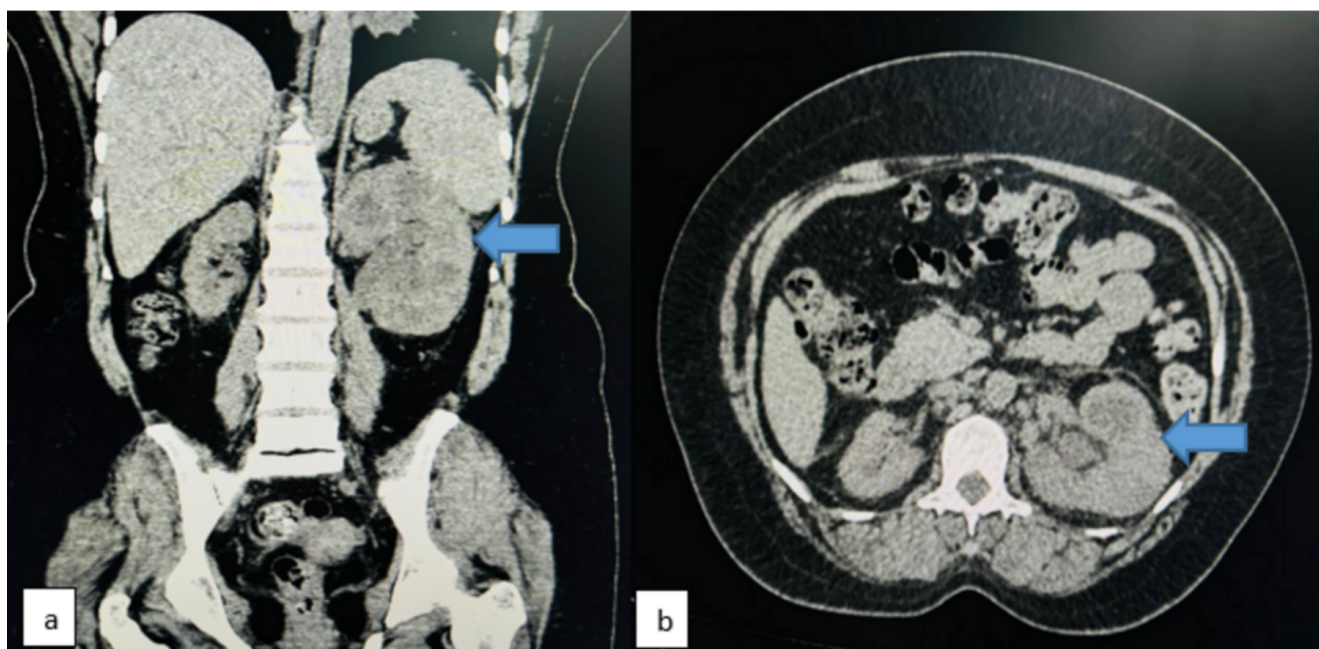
The CT scan reveals an enlarged left kidney exhibiting heterogeneous attenuation, along with perinephric fat stranding, as indicated by the blue arrow in the frontal (a) and axial (b) views.
